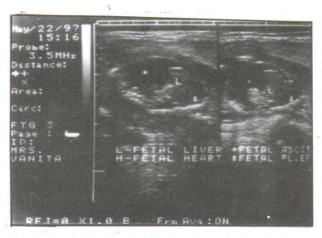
Sonogram showing fetal ascitis and pleural effusion.
